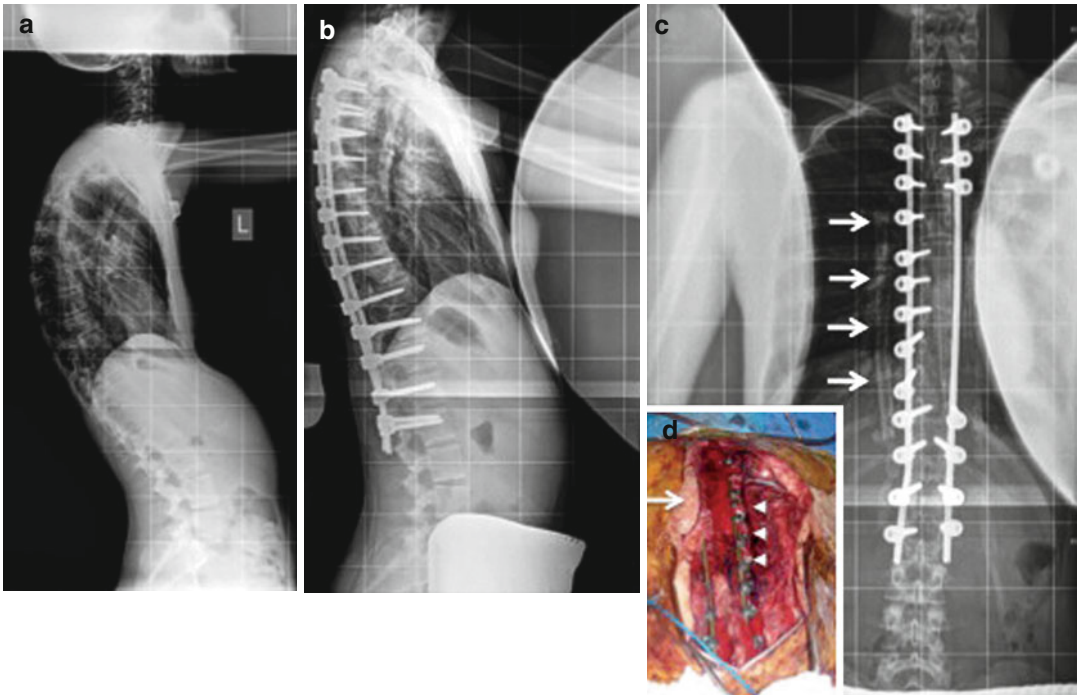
(a) Standing scoliosis lateral radiograph showing patient’s kyphosis. (b) Postoperative standing scoliosis lateral radiograph showing correction of kyphosis following monoaxial pedicle screw and rod fusion with vascularized fibular graft. (c) Postoperative AP radiograph with fibular graft visible (arrows). (d) Intraoperative
